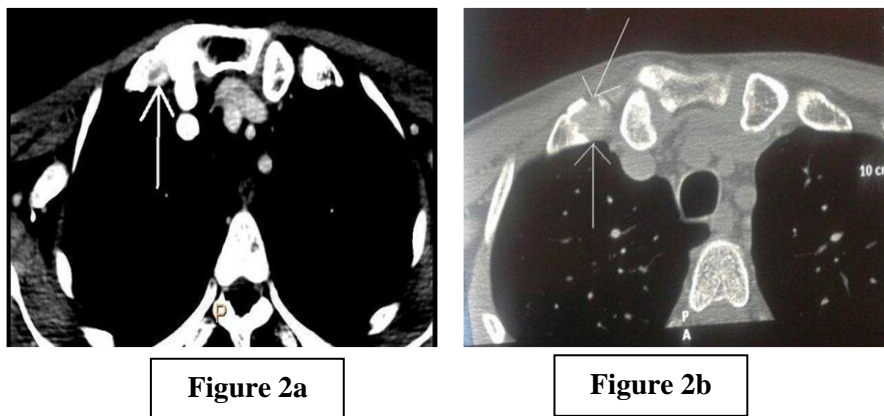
Contrast enhanced CT scan axial section at the level of right first rib adjoining sterno-clavicular joint. Figure 2a - Mediastinal window shows destruction of the anterior end of the first rib of the right side (white arrow) with the soft tissue involvement. Figure 2b - Bone window of the same region showing lytic lesion with destruction (white arrows).
